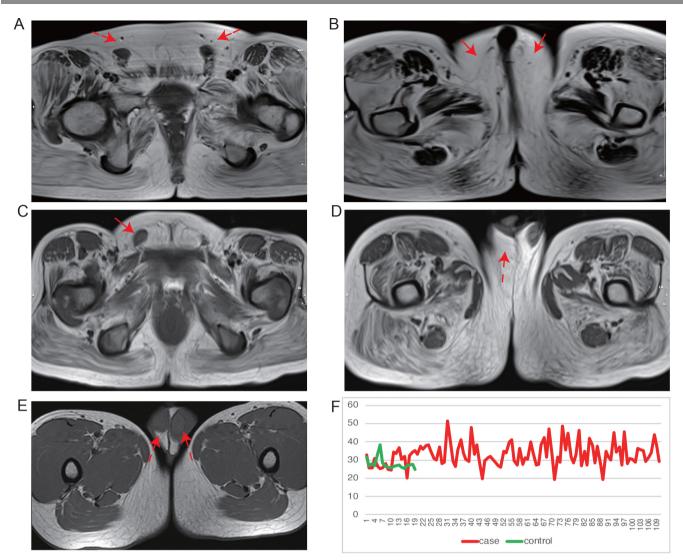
The MRI and sequencing depth. (A–E) The two MRI graphs for bilateral cryptorchidism (case B130). (C, D) The two MRI graphs for unilateral cryptorchidism (case U111). (E) The MRI for one control. The red arrows show the location of the testes. (F) The whole-genome sequencing overall depths for the cases (red) and control (green).
